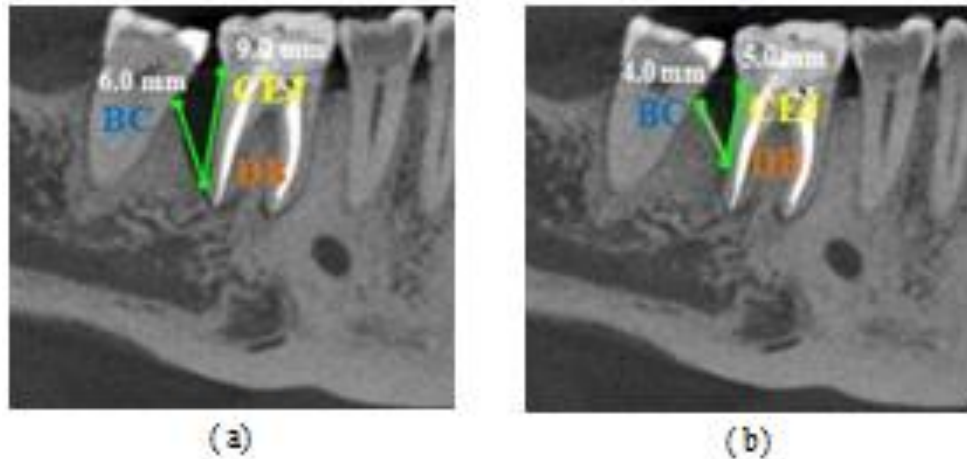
CBCT of lower right quadrant showing first molar with distal defect depth equals to 9.0 mm at baseline (a) and 5.0 mm at 6 months after surgery (b).
